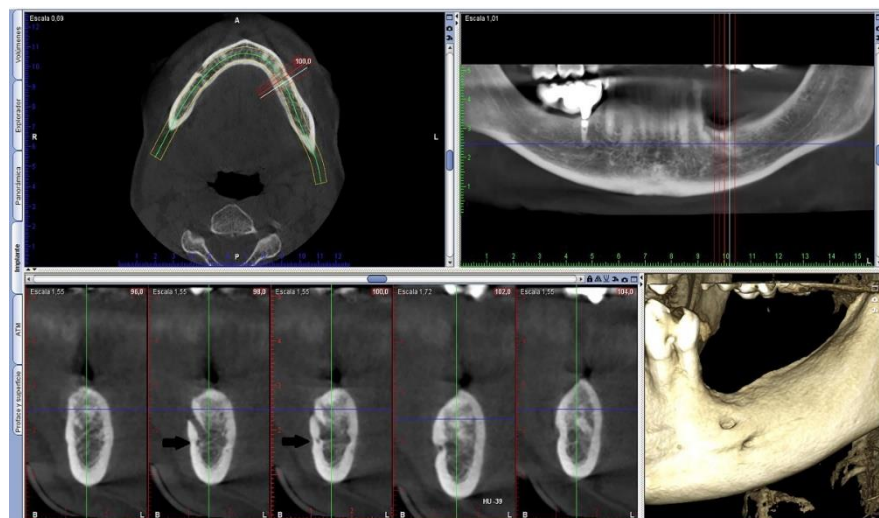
CBCT reconstructions of a 65-year-old male patient with an accessory mental foramen in the left hemimandible. The accessory mental foramen is placed posteriorly and inferiorly to the mental foramen (Planmeca Romexis Software®).
